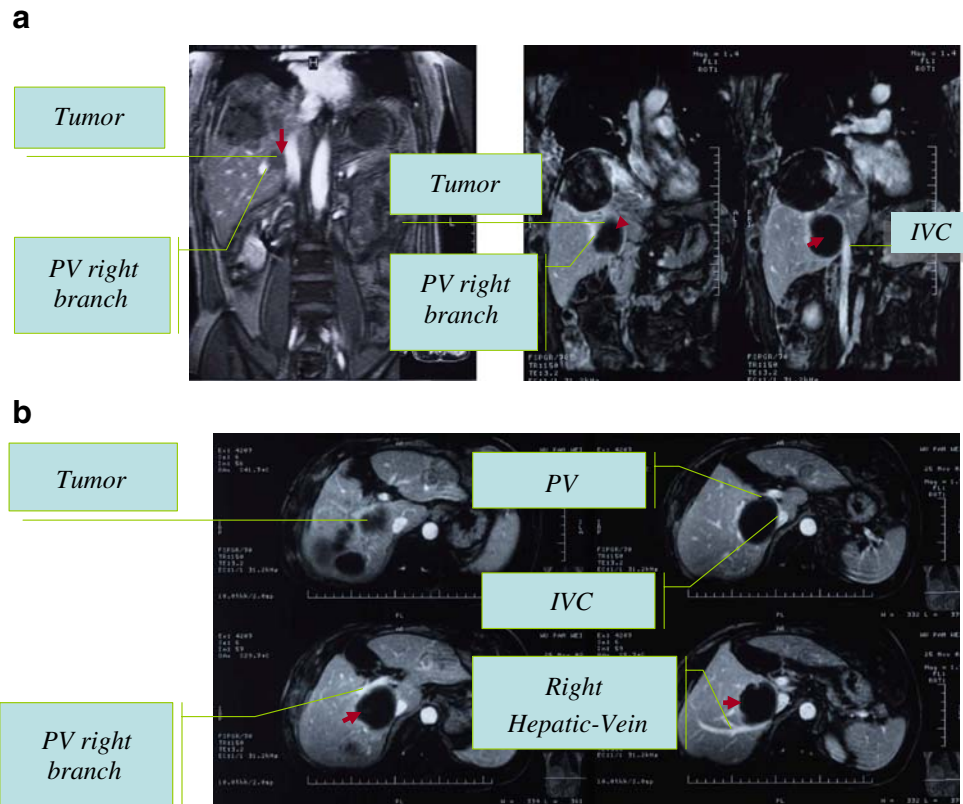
Contrast agent-enhanced MR images of a 68-year-old patient (case 2) with HCC. a Before HIFU (*left*). Coronal enhanced MR images show a tumor (*arrow*) located between the right branch of portal vein and the inferior vena cava (*IVC*). After HIFU (*right*). There was no enhancement in the treated region (*arrow*), and no damage to inferior vena cava were observed 2 weeks after HIFU
